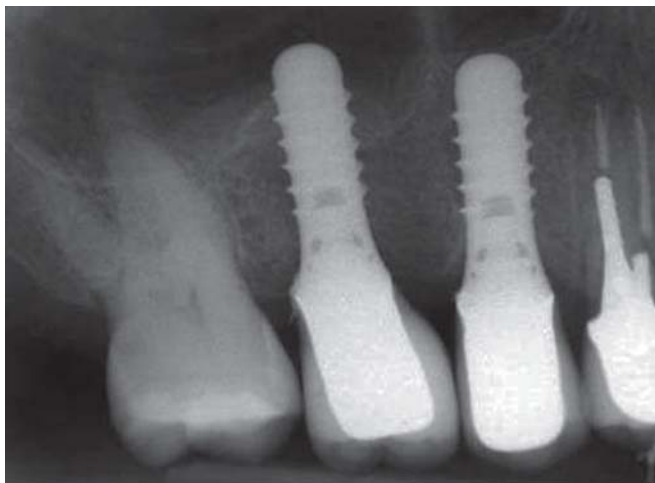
Periapical radiograph after 2 years of prosthetic loading showing stable condition at SFE site
